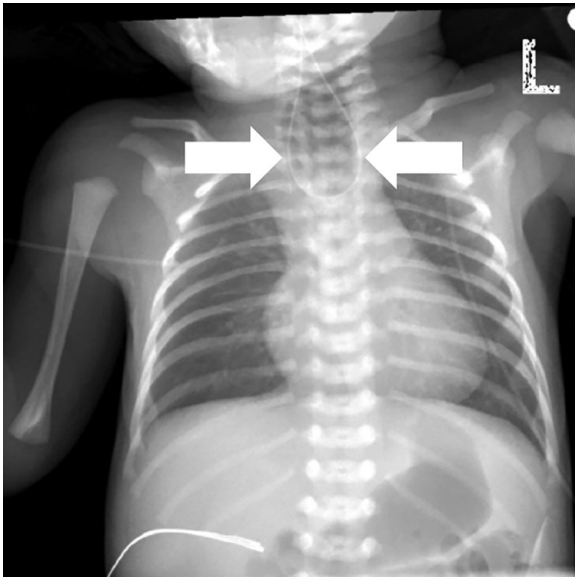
Chest X-ray of infant with tracheoesophageal fistula revealing coiling of gastric tube in the upper gastric pouch. Reproduced from: Adler AC, et al. *A A Case Rep* 2017;8(7):172–174. Copyright © 2017 International Anesthesia Research Society
